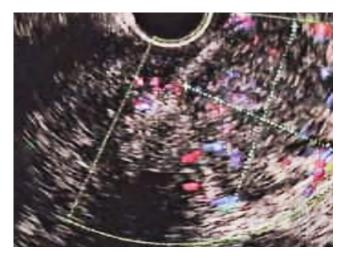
Endoscopic ultrasound showing a heterogeneous lesion in the fourth echolayer, measuring 23 x 26 mm, consistent with a GIST. Source: Gastroenterology Department, Hospital Cayetano Heredia.
